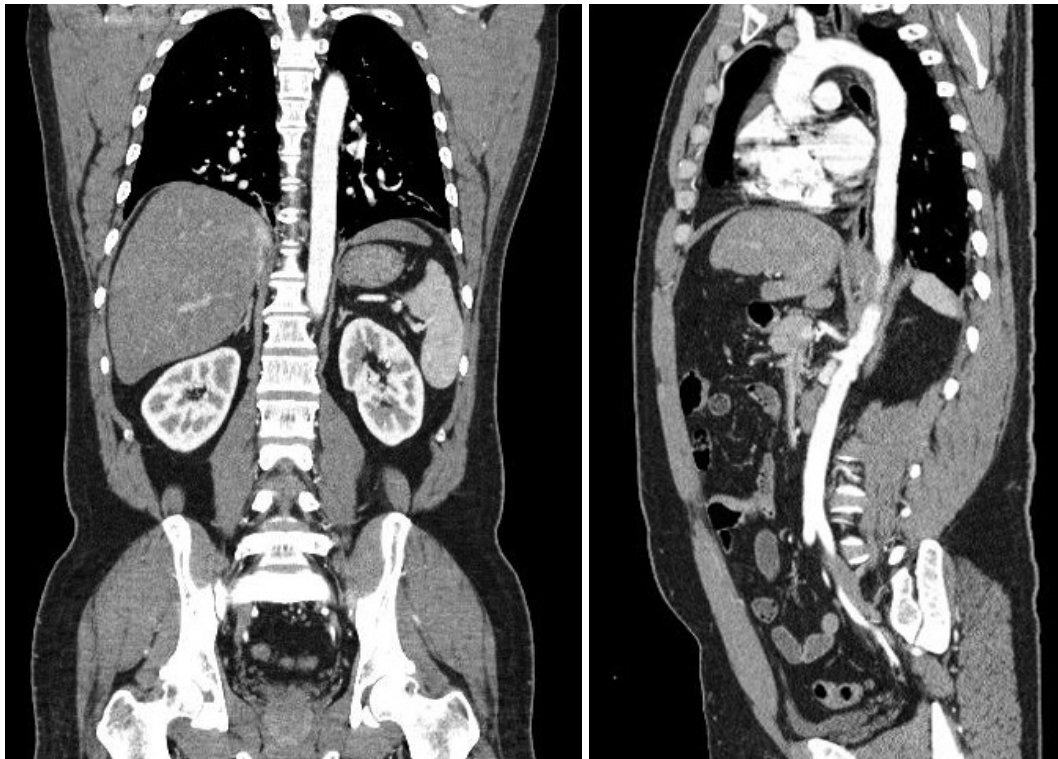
A case of negative coronary angiography and dedicated aortic CT angiography in a 42-year-old male patient with nonspecific acute chest pain. The patient presented with severe acute chest pain in both the anterior chest and back. Emergent coronary angiography was negative. Dedicated aortic CT angiography performed on the next day was also negative. The cause of acute chest pain in the patient was determined to be esophageal spasm.
